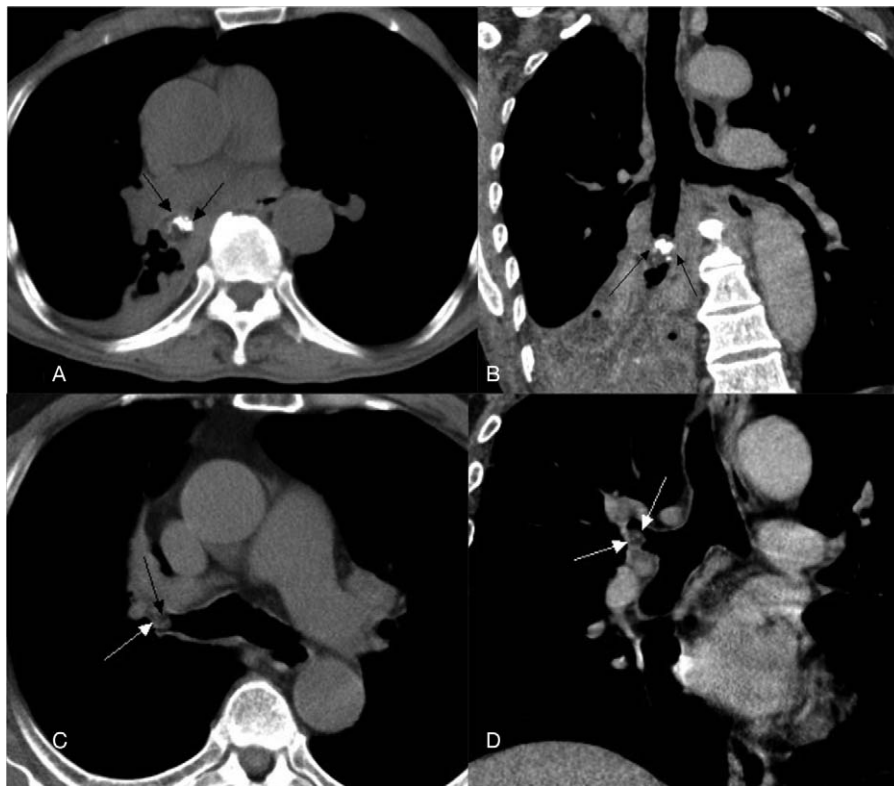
(A–D) Advantages of using MPR images (A and B are from one case, and C and D are from another case). (A) and (C) are axial CT images that demonstrate the hamartomas, but the axial images cannot clearly display the relationship between the location of the tumor focus and adjacent bronchus and the lack (or presence) of bronchial wall thickening. (B) and (D) are MPR images which are parallel to the bronchial long axis and clearly display the acute angles included between the tumor focus and adjacent bronchial wall. These images also help demonstrate lack of adjacent bronchial wall thickening or discontinuity, features that aid in the diagnosis of a benign hamartoma. MPR = multiplanar reformation.
